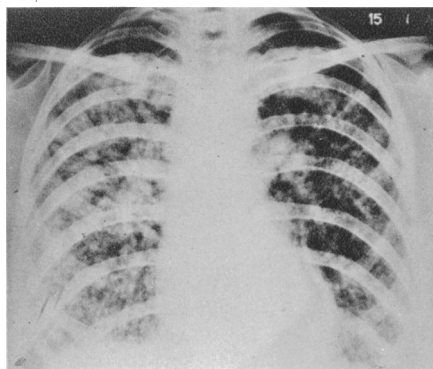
Case 11. Radiograph of chest; FIG. 9.—Case 11. Radiograph of chest; January, 1948.
